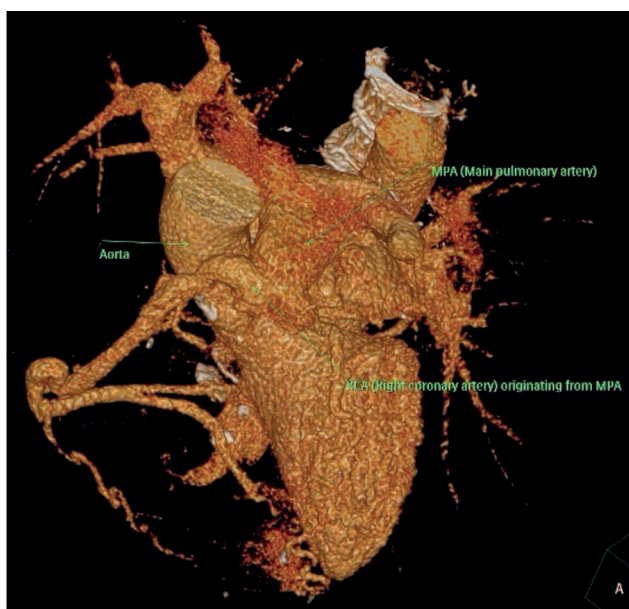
Reconstructed cardiac computed tomography showing right coronary artery originating from the main pulmonary artery.
